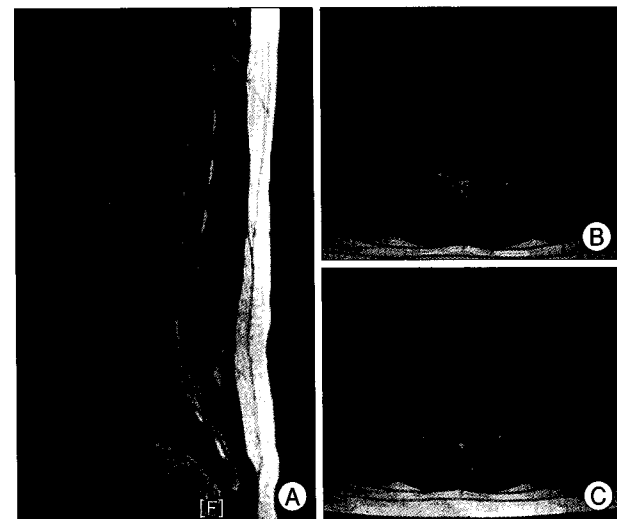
Magnetic resonance images of the patient. A : T2 sagittal magnetic resonance image reveals severe degenerative change at L2-L3, L3-L4, and L4-L5 levels and disc protrusion at L3-L4 level. B and C : T1 and T2 axial magnetic resonance images show left posterolateral disc protrusion at L3-L4 level.
